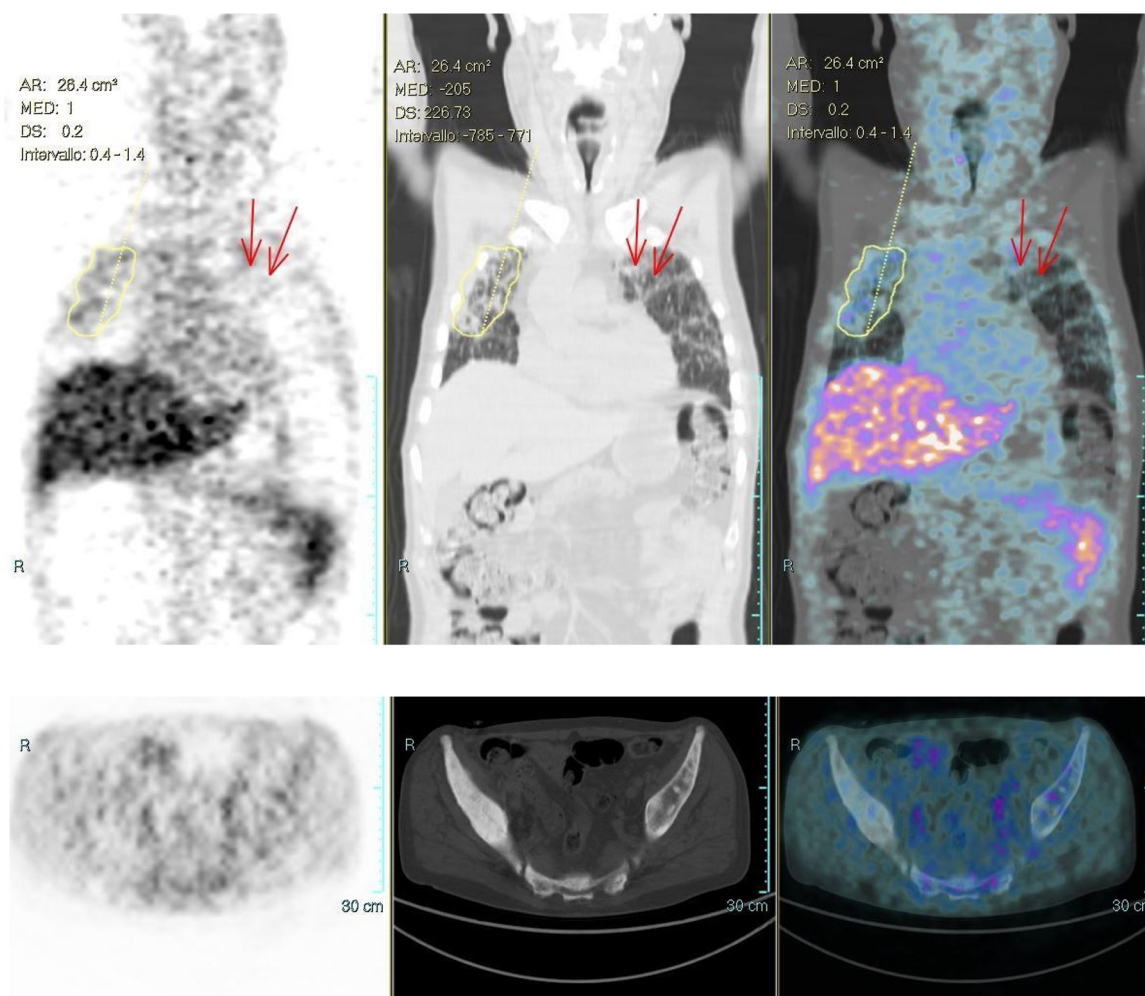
(A) ^{68}Ga -DOTANOC PET/CT coronal view showing bilateral lung mild uptake (yellow circle area on the right, red arrows on the left). The final radiological diagnosis of lymphangitic carcinomatosis was reached by consensus, in accordance with the CT scan findings, and on the basis of clinical findings. (B) ^{68}Ga -DOTANOC PET/CT transaxial view is showing negligible uptake in the diffuse osteoblastic and mixed skeletal metastases (transaxial view). (For interpretation of the references to color in text, the reader is referred to the web version of the article).
